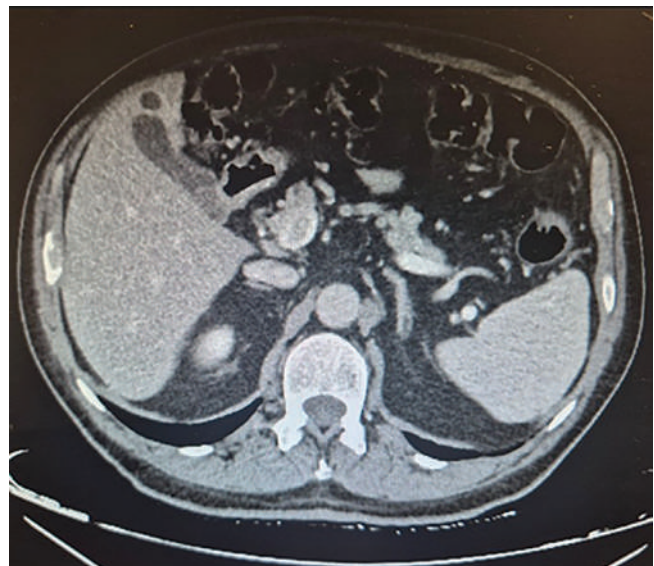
Intrahepatic gallbladder computed tomography imaging.
